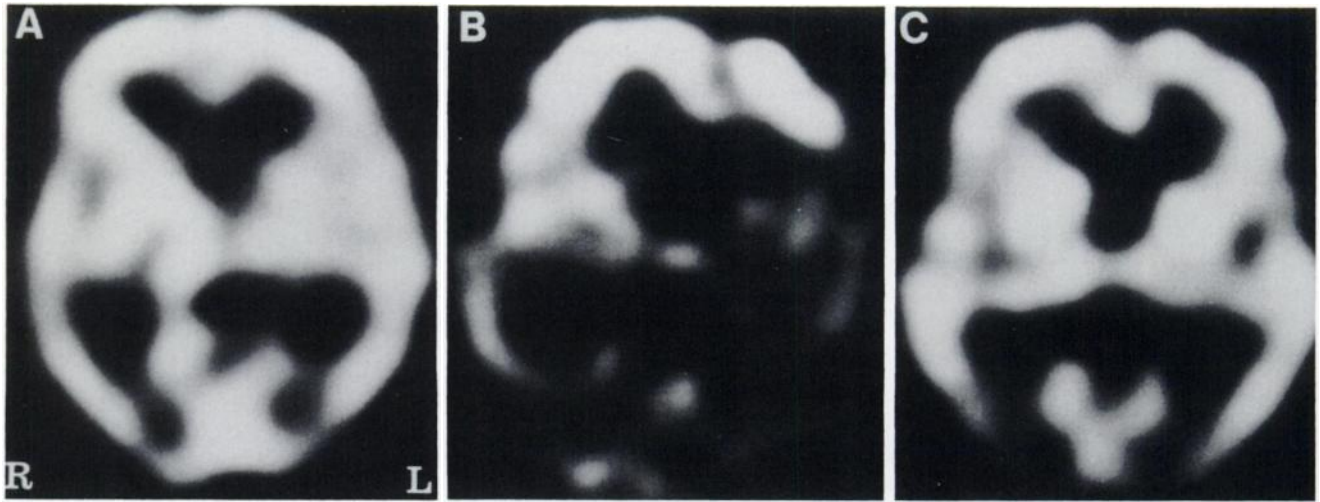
(A) SPECT image before the onset of symptoms shows no abnormality. (B) SPECT image on Day 5 after the onset of the disease shows generalized rCBF reduction on both sides of the parietal cortex, temporal cortex, visual cortex, basal ganglia and thalamus, and a preserved flow in the bilateral frontal cortices. (C) SPECT image on Day 49 shows partially restored flow on both sides of the parietal and visual cortices and normalized flow in the temporal cortex, thalamus and basal ganglia. The relative flow in the frontal cortices shows a modest decrease from that of the acute stage. Images are displayed at the level containing the thalamus and the basal ganglia with a gray scale from 15% to 100% of the maximum counts.
